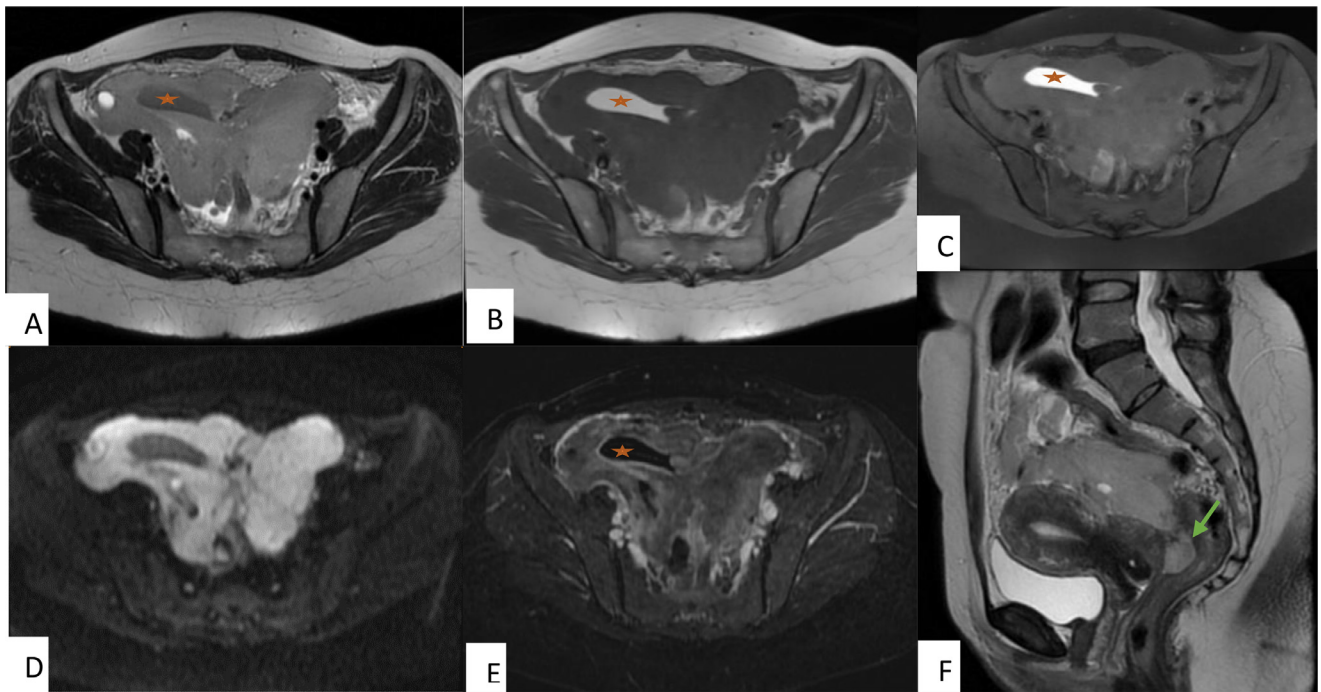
Pelvic magnetic resonance imaging (MRI), including axial T2WI (A), T1WI (B), T1-weighted fat-suppressed images (C), diffusion (D), dynamic contrast-enhanced images (E) and sagittal T2WI (F): the tumor presented heterogeneous intensity on T2WI and T1WI with restricted diffusion, including areas “that were hyperintense on T1WI, not erased on T1-weighted fat-suppressed images, hypointense on T2WI, and did not enhance after contrast (orange star).” This mass extended to the Douglas and invaded the uterus and the rectum serosa (green arrow). No abnormality was suspected in the endometrium.
